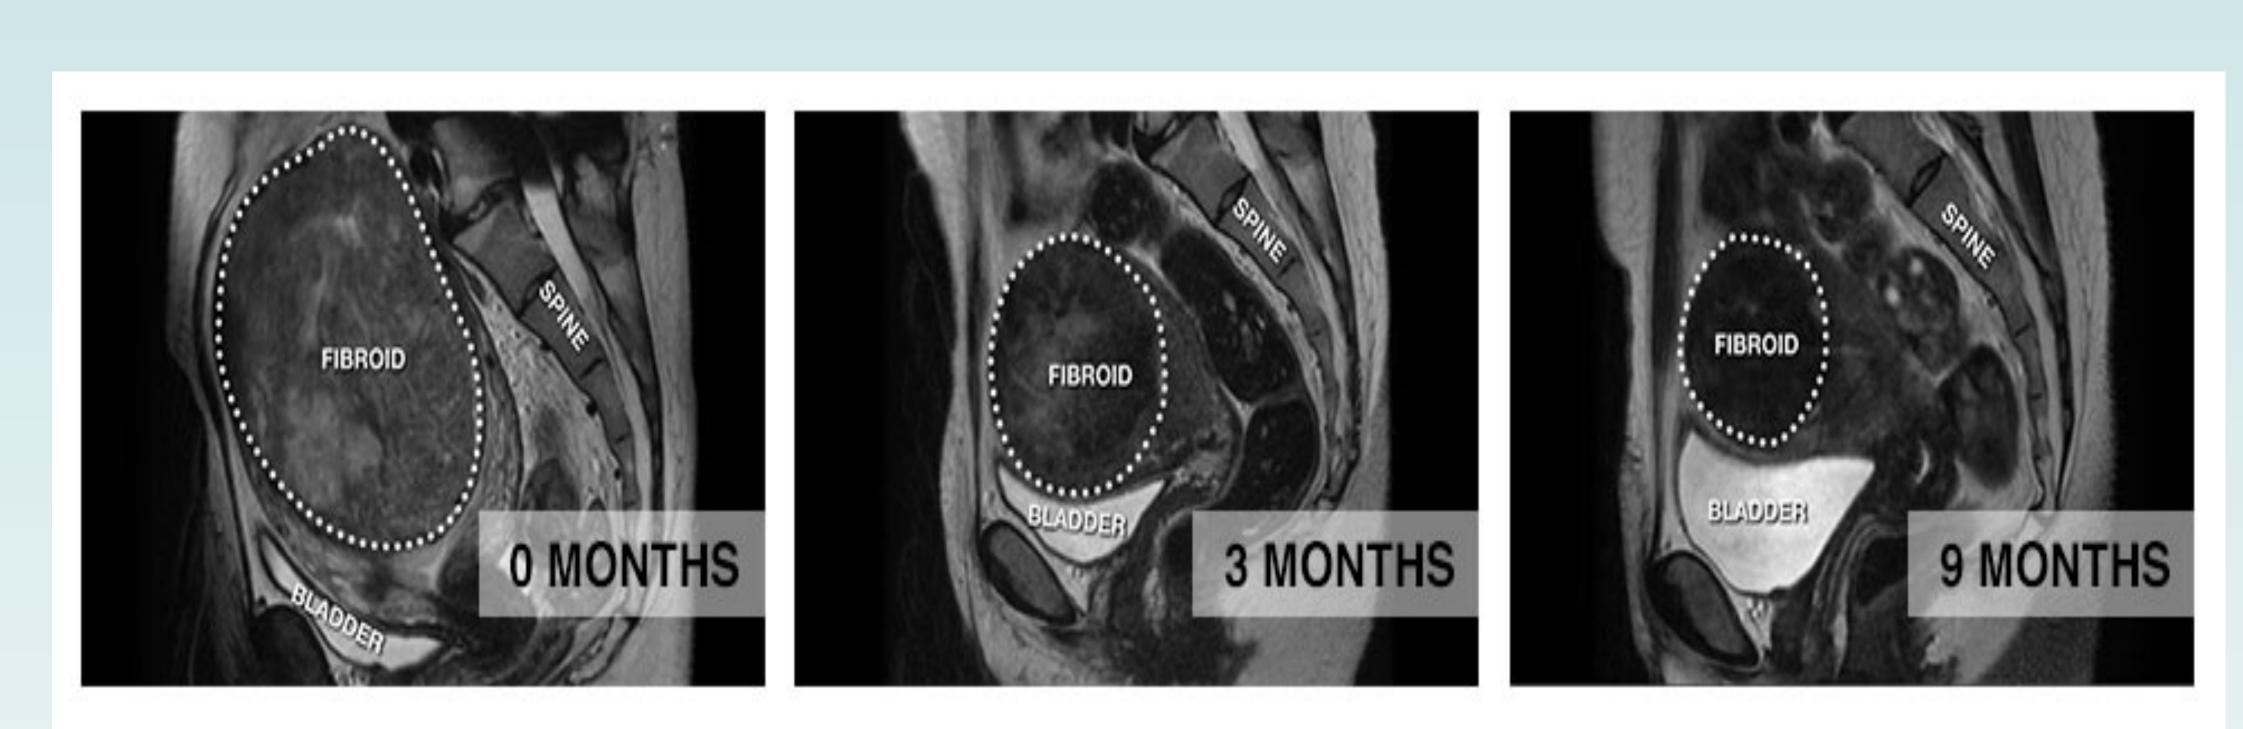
MRI showing fibroid size comparison at 0, 3, and 9 months following uterine fibroid embolization
